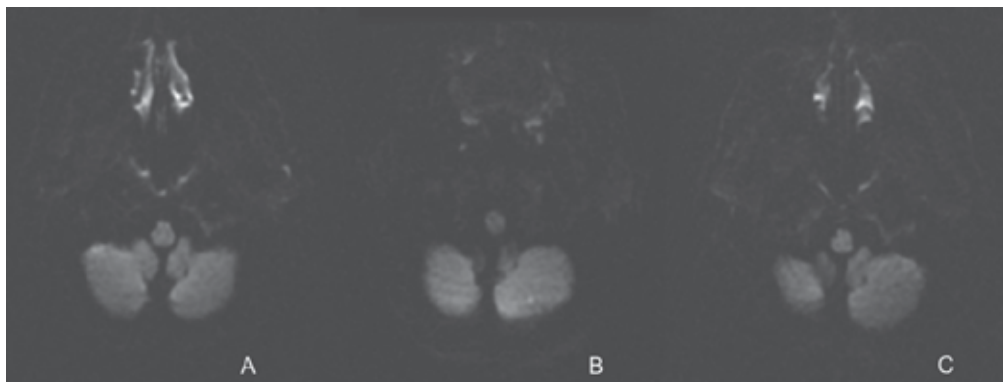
Patient number 19, 81 years old with bilateral stenosis in the carotid arteries. A DSA was performed in the aortic arch, common carotid arteries, left subclavian artery, and brachiocephalic trunk before the CAS of the left carotid artery. Diffusion study before the DSA and angioplasty (A). After DSA and CAS, an NF was identified in the DWI in the left hemisphere of the cerebellum (B). A new MRI performed 40 days after the CAS (not as part of the study protocol) showed the absence of lesions in the DWI (C) and in T2 (not shown).
